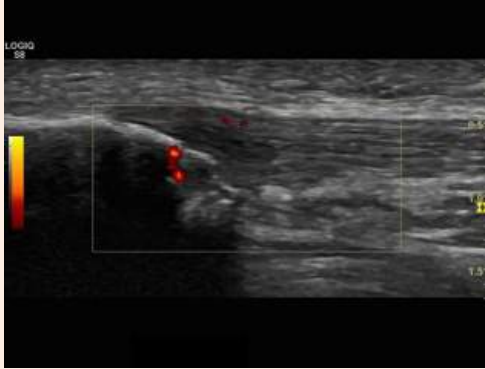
Ultrasound image in longitudinal view and colour Doppler two weeks after the EPI® technique treatment ultrasound-guided. It is observed the degenerated area of the tendon that is substituted by a new connective tissue and decrease the neovascular effect.
